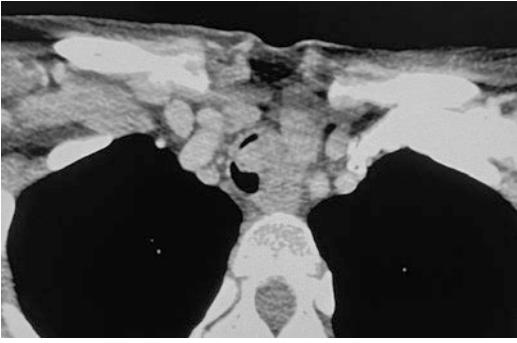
Axial CT scan with iodine contrast of a patient presenting with an SCC at the junction between cervical and thoracic trachea
